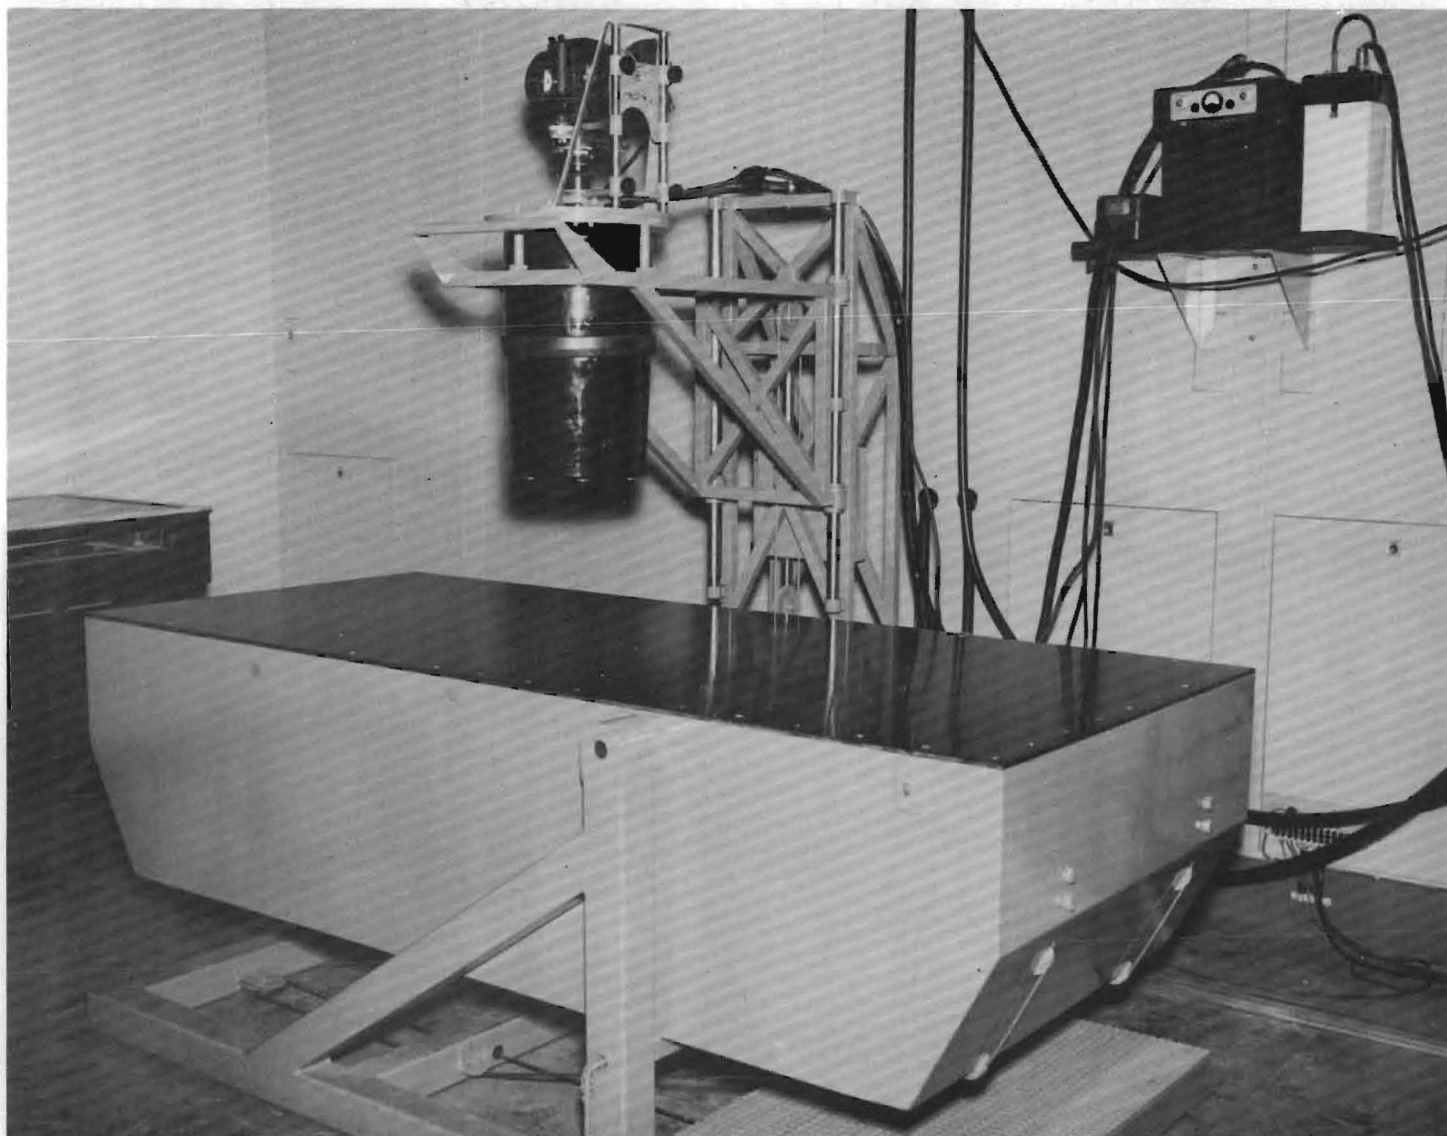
View of the Special X-Ray Table in a Horizontal Position.
